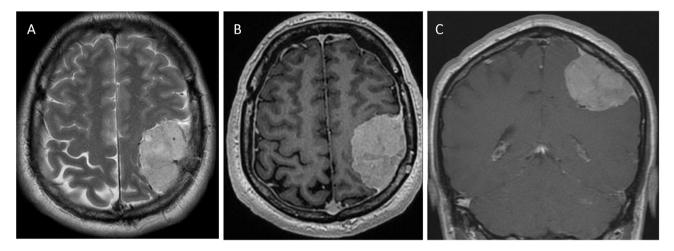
Left temporal meningioma showing hyper-intensity on T2-weighted axial MRI (Fig. 2A) with homogeneous Gadolinium enhancement on axial (B) and coronal (C) T1 sequences.
